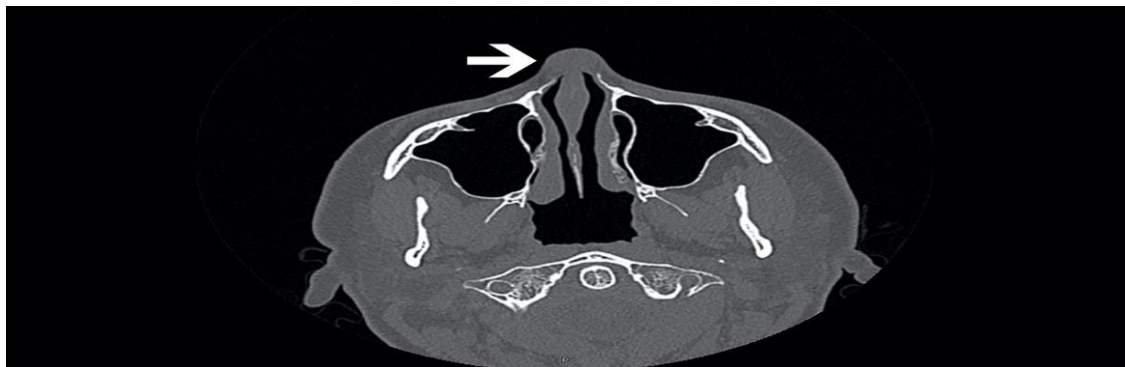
There was a nasal dorsal roof defect on the CT scan, including a low-density mass located on the defected nasal bone extending towards upper lateral cartilages (ULC). White arrow shows soft tissue mass on the nasal dorsum.
